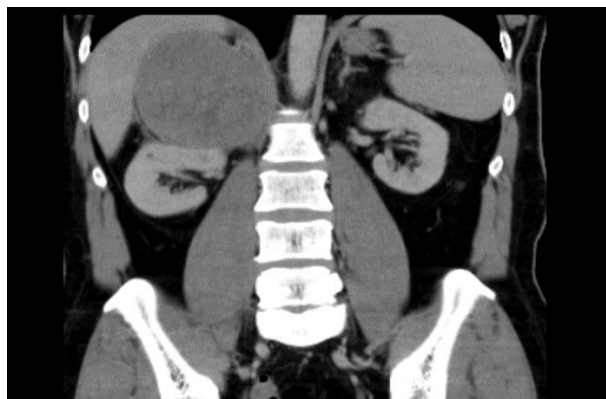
Pre-surgery CT scan showing a large adrenal mass above the right kidney.
